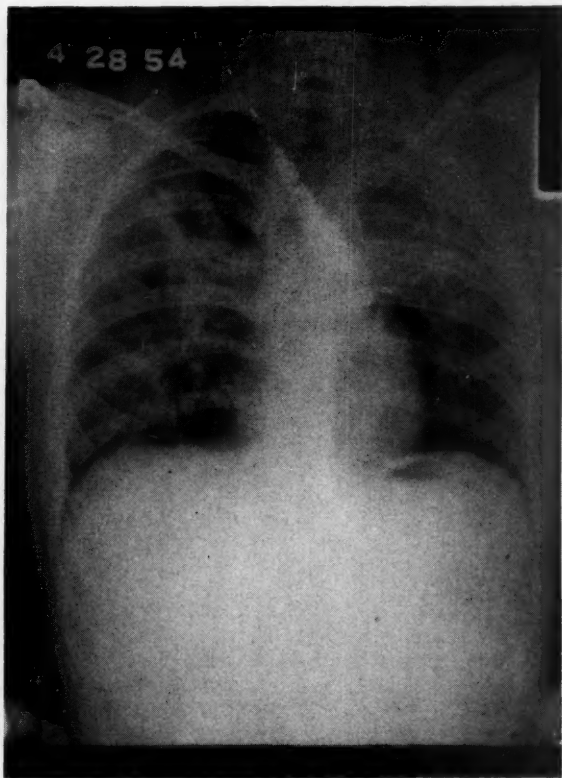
Chest x-ray just prior to corticosteroid therapy. Note progression of disease since first x-ray.
